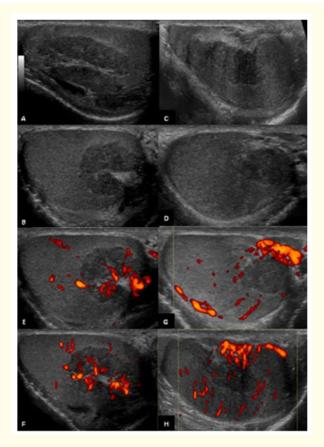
Testicular adrenal rest tumors (TARTs) in an asymptomatic 16-year-old boy with poorly controlled neonatal CAH (patient# 3). Grey scale US images A, B (longitudinal and transverse images of right testicle), C and D (longitudinal and transverse images of left testicle) show a well-defined lobulated heterogeneous hypoechoic oval shape mass adjacent to the mediastinum testis bilaterally. Color Doppler US images of the right (E, F) and left (G, H) testicles show testicular vessels coursing undisturbed through these masses, without any displacement or change in caliber.
